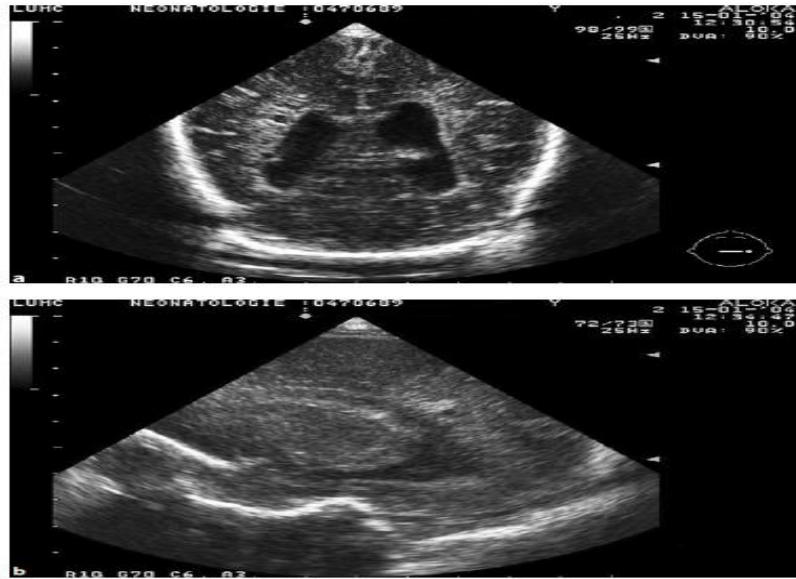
Ultrasound scan in a preterm infant with cystic periventricular leukomalacia, showing cystic lesions and increased echogenicity in the parietal periventricular white matter, seen in two image directions. a Coronal scan at the level of the trigone of the lateral ventricles. B Parasagittal scan through the right lateral ventricle
